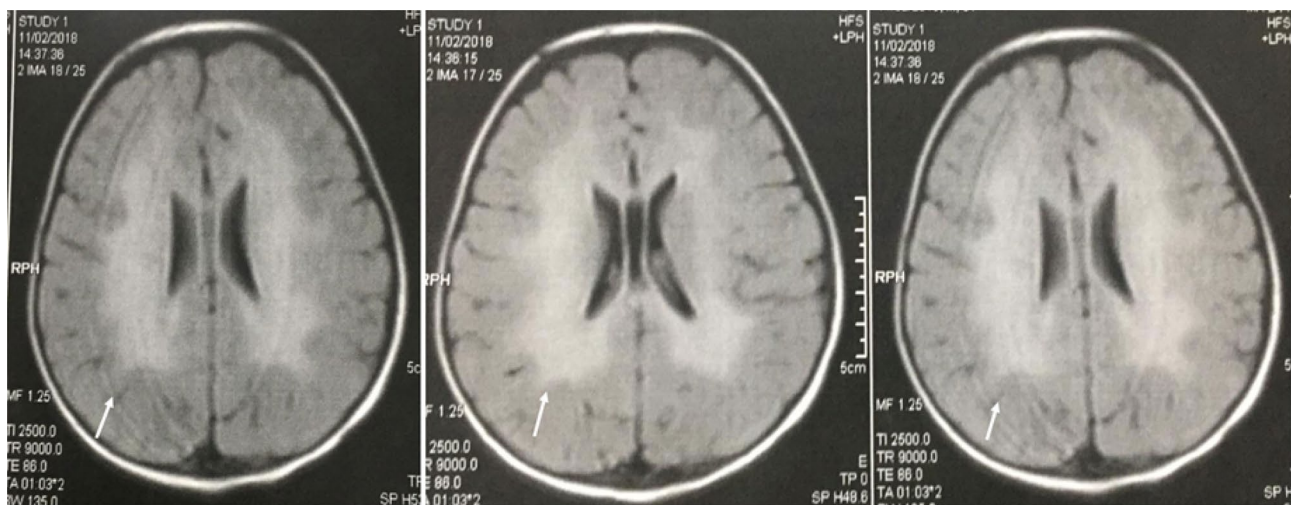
Brain MRI. T2-weighted MRI of the brain in MLD patient 31 revealed white matter hyperintensities (arrow)
